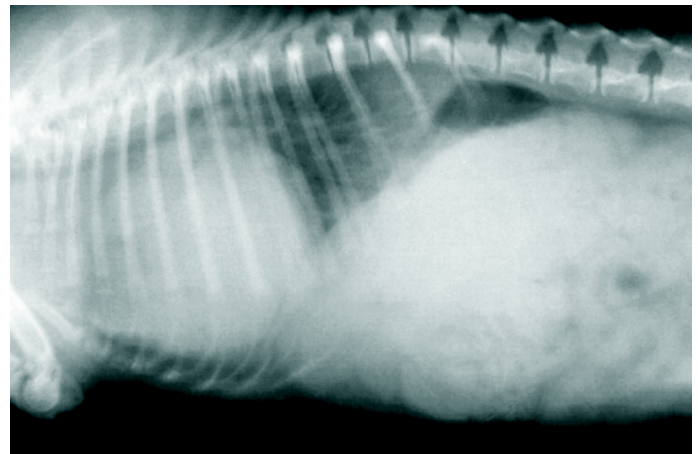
Right lateral thoracic radiograph. Note markedly enlarged and rounded heart silhouette and indistinct diaphragm dome outline
